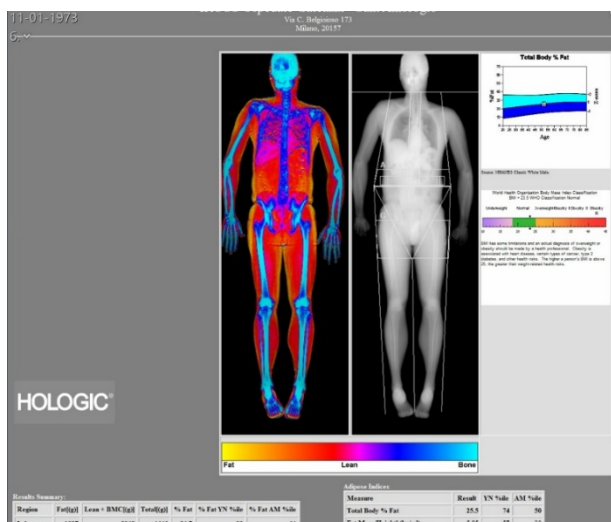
Dual-energy X-ray absorptiometry (DXA) body composition scan of a male and a female patient. Image A shows a 52-year-old man with out sarcopenia, with a value of Append. Lean/Height² (ALMI index, see the red circle) of 7.54 kg/m² (normal values > 7.0 kg/m² for men according to EWGSOP2). Conversely, image B shows a 82-year-old woman with a DXA-based diagnosis of sarcopenia and a very low value of Append. Lean/Height² (red circle, ALMI index) of 5.57 kg/m² (normal values > 6.0 kg/m² for women according to EWGSOP2)
